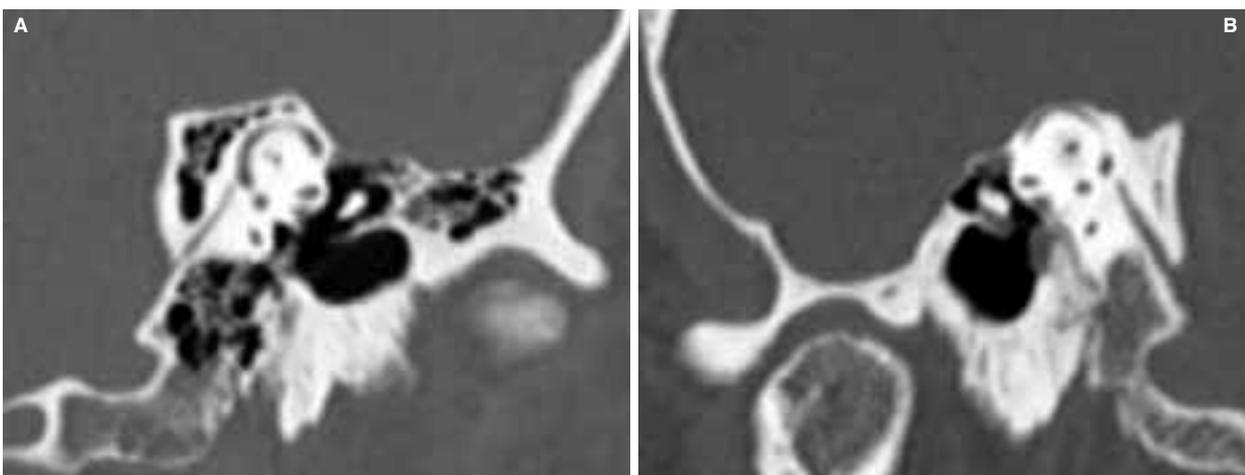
Temporal bone CT scans across the plane of the superior canal. A. Normal superior canal has bone overlaying the superior aspect. B. A dehiscence canal has no bone.
